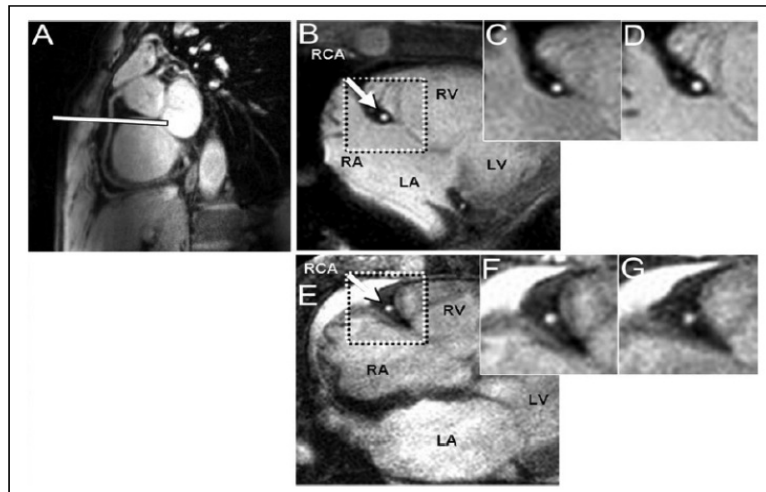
Typical anatomical coronary images using MRI at rest (image C and F) and with sequential handgrip stresses (image D and G) in a healthy subject (image B,C,D) and CAD patient (image E,F,G). Image A shows the scout scan with the location of the cross-sectional imaging plane placed perpendicular to the right coronary artery (white line). Image from reference [10]
